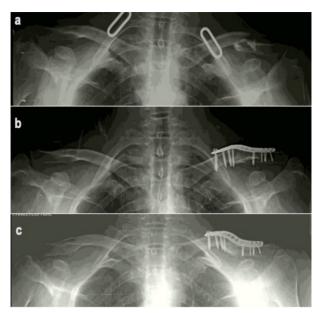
The preoperative radiograph shows a nonunion case of mid-shaft clavicle following the initial non-surgical treatment (a). The postoperative standard radiographs demonstrate continuity of cortex as evidence of union at the nonunion site (b and c).
